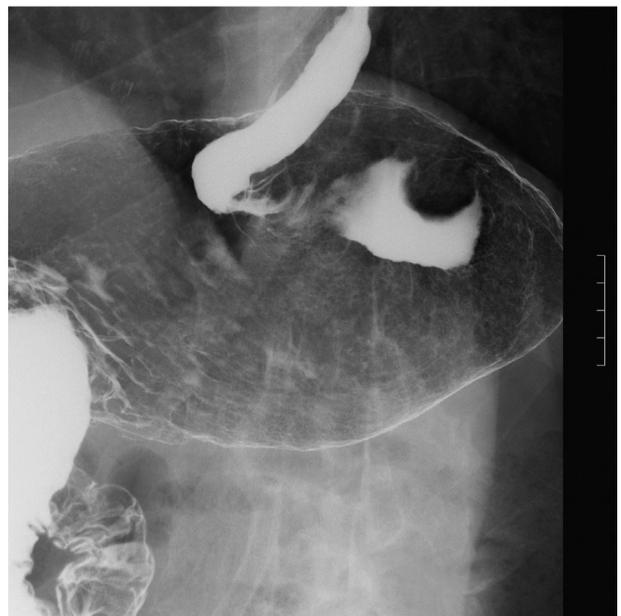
Double-contrast radiograph showing an elevated lesion in the posterior upper-third of the stomach. The diameter of the contrast deflection was 25 mm.
